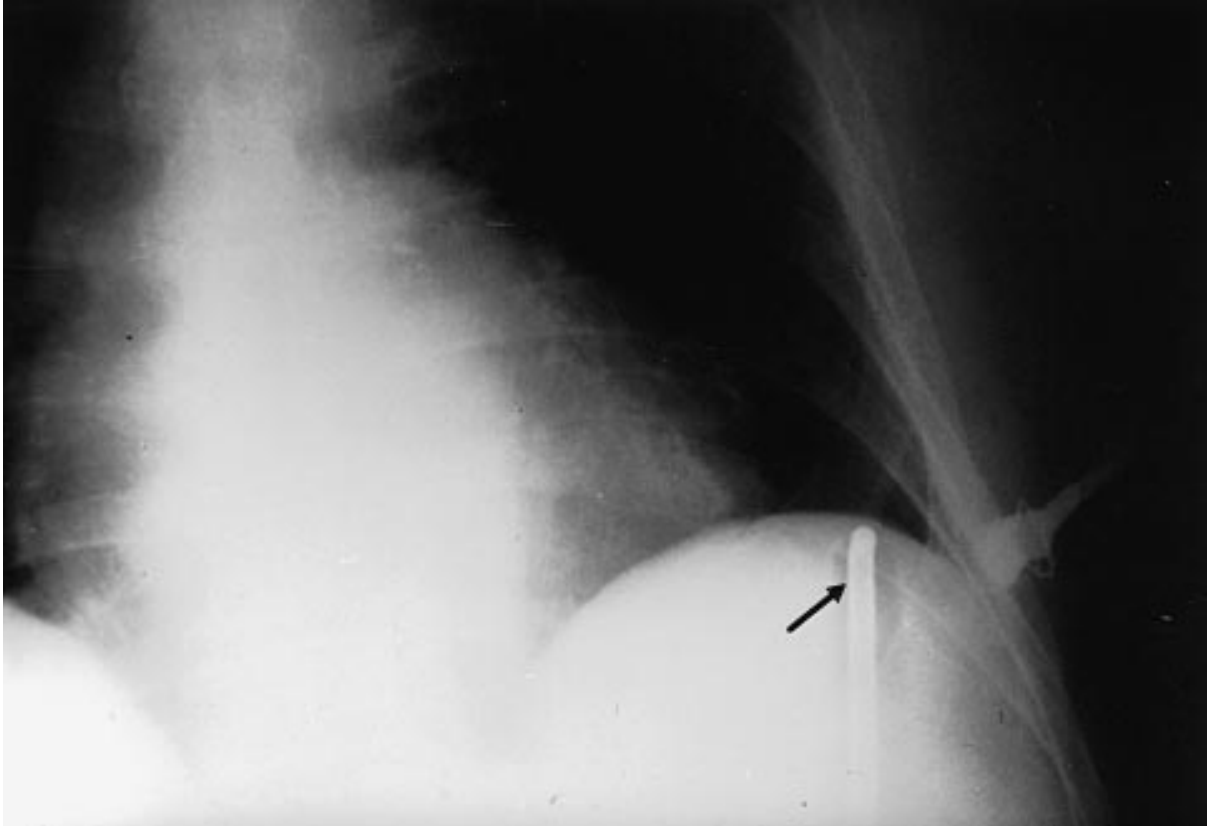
Postmortem abdominal X-ray showing tip of IABP lying free beneath the left dome of diaphragm (arrow).*
